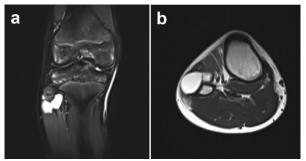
(a) Coronal STIR MRI cut and (b) Axial T2 MRI cut: showed well-defined a fluid intensity lesion at the anterolateral aspect of the right proximal tibiofibular joint compression common peroneal nerve
